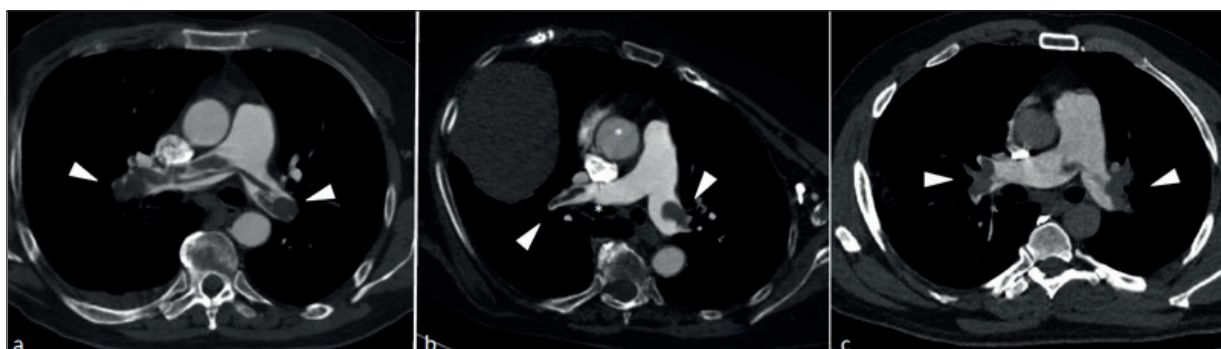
Three cases of PE (white arrowheads). Image a) and c), show a saddle pulmonary embolism. Adequate opacification was obtained in all CTPA (i.e., HU \geq 90). However, different technical errors were observed. Image a) shows a delayed acquisition with higher contrast medium amount, opacifying also the aorta. Image b) shows more evident striking artifacts (white asterisk) than image c), due to the higher amount of contrast medium in superior vena cava. PE: pulmonary embolism; CTPA: computed tomography of pulmonary artery; HU: Hounsfield unit.
